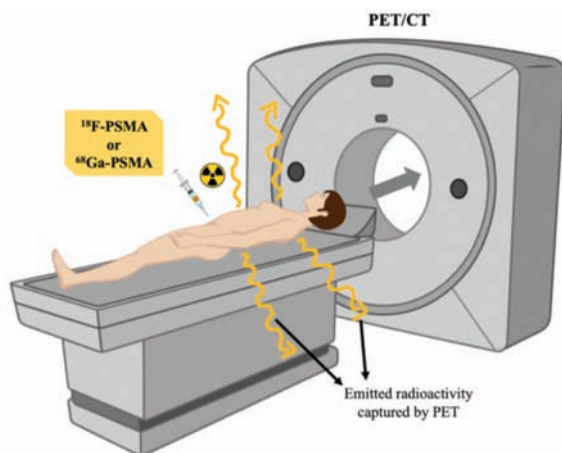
PET/CT imaging. The radioactivity emitted by the radioisotopes ^{18}F or ^{68}Ga bound to PSMA ligand is captured by PET/CT, enabling images to be obtained. ^{18}F -PSMA or ^{68}Ga -PSMA is injected approximately 60 minutes before PET/CT imaging. The patient lies under the camera for less than 20 minutes.
